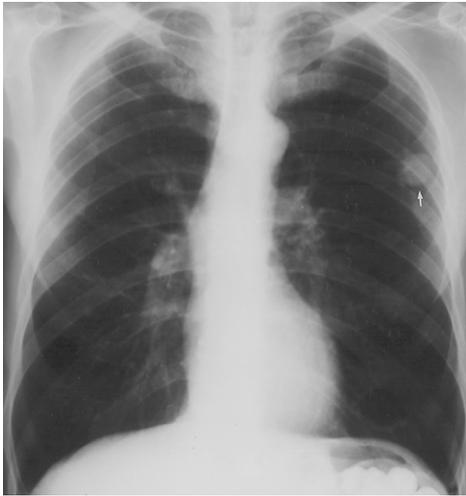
Coccidioidoma. PA chest radiograph of a 61-year-old asymptomatic man demonstrates a left upper lobe ovoid, non-calcified solitary pulmonary nodule (arrow). Biopsy demonstrated a fibrocasseous granuloma of coccidioidomycosis.
